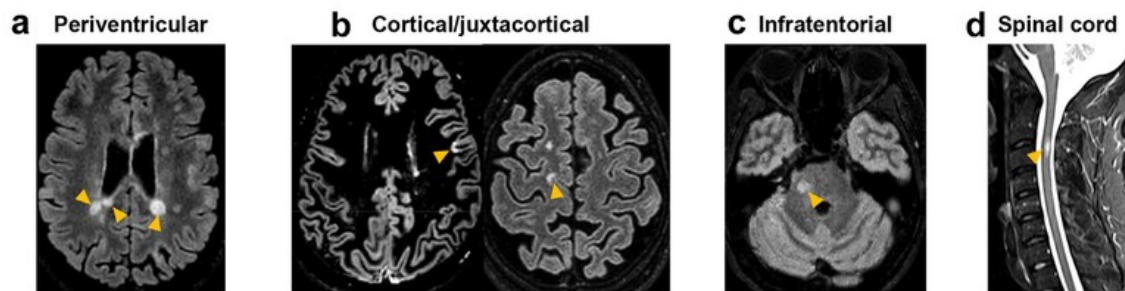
Typical MRI examples of MS lesions. (Reprinted from Rocca et al. 2024, under the terms of the Creative Commons Attribution License, CC BY 4.0)
